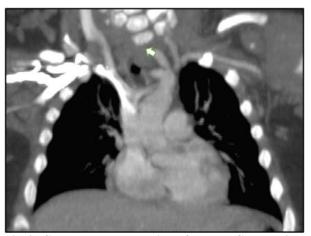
Coronal reconstruction of a chest CT showing the left subclavian artery (arrow)
